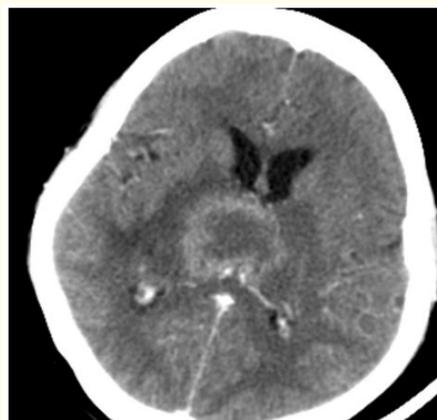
CT brain (a)- Non contrast study shows well-defined hypodense lesion involving both thalami with a thick hyperdense rim (b) Contrast study shows peripheral enhancement of the lesion. Note the surrounding edema.
